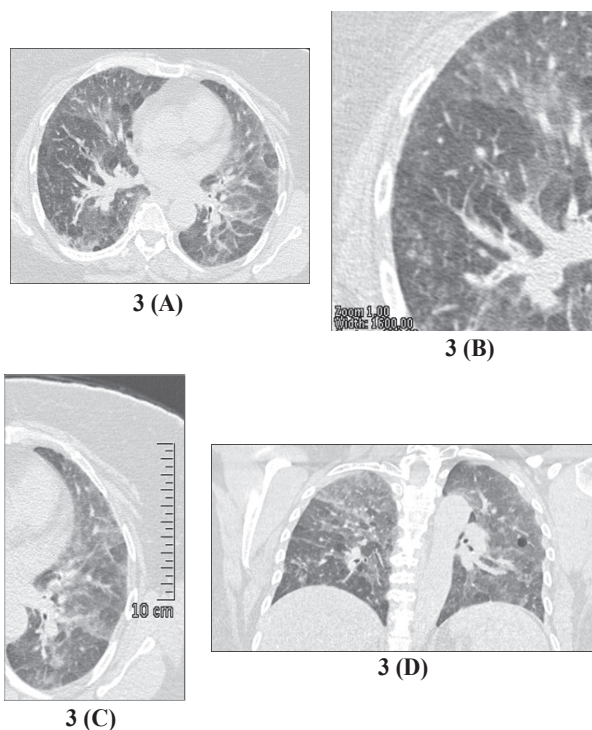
(A-C) Axial HRCT (D) Coronal HRCT Showing Patchy Ground Glass Opacities with Mosaic Pattern Predominately in the Middle Zones and Upper Lobes. Patchy Centrilobular Nodules are seen in the Posterior Segment of the Right Upper Lobe
